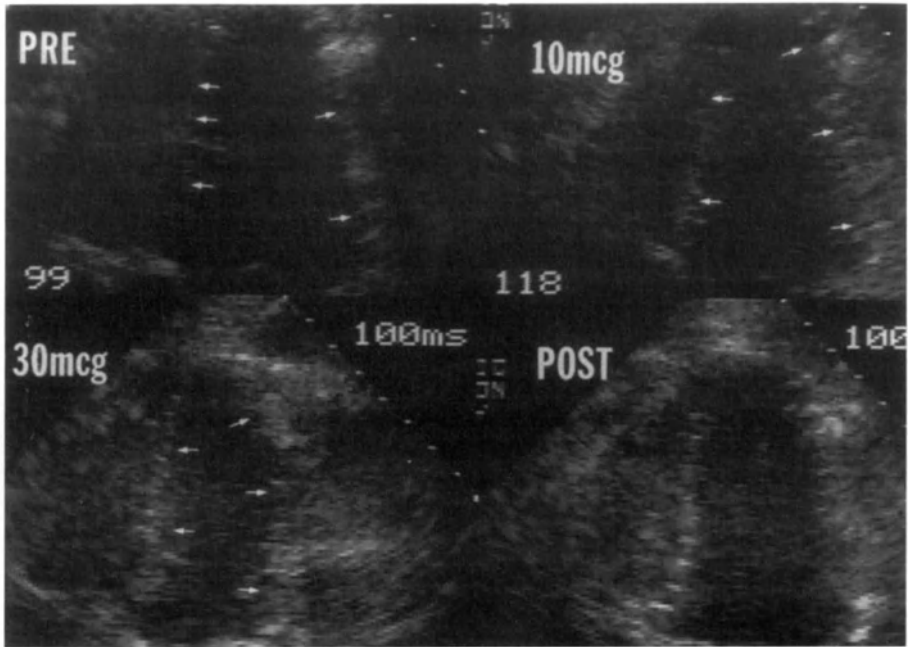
End-systolic images from a dobutamine echocardiogram, showing normal function at rest, little change at low-dose, hyperkinesis (arrows) at high-dose, and rapid resolution post-stress. Reproduced with permission of the American Journal of Cardiac Imaging.
